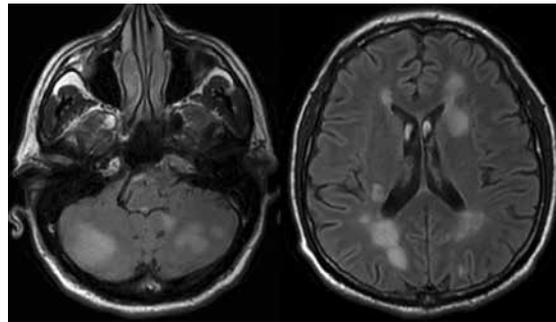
Numerous lesions can be observed in the posterior fossa and supratentorial region located subcortically and at deep white matter level, as seen in the axial FLAIR slices.
